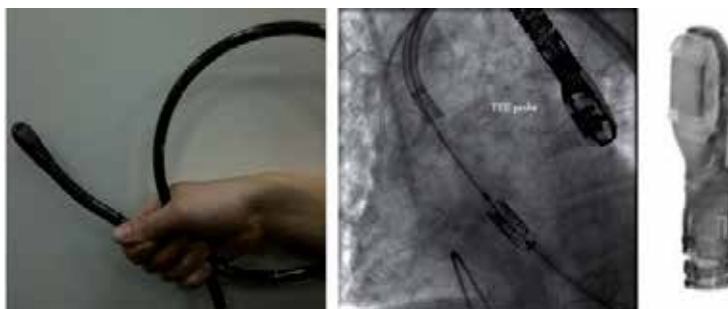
The TEE probe and its tip sensor used to image left atrium or pulmonary veins during ablation procedures. Also shown is the TEE probe visible in X-ray. Image taken from King et al., 2010.
